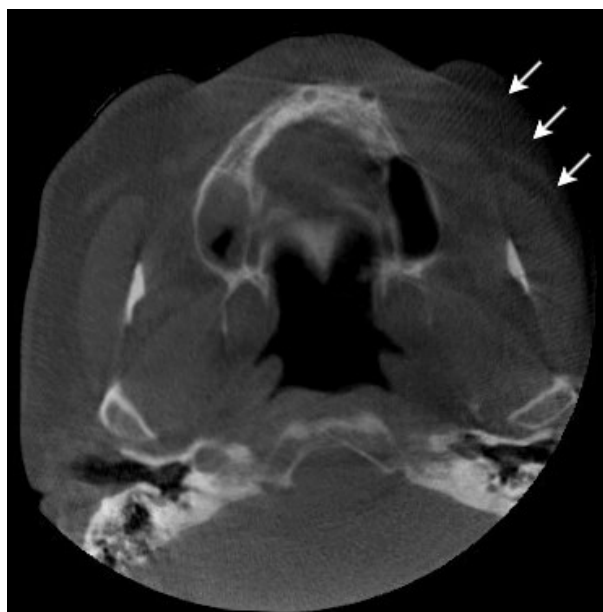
Moire artifact (white arrows) is demonstrated in the axial CBCT image.
